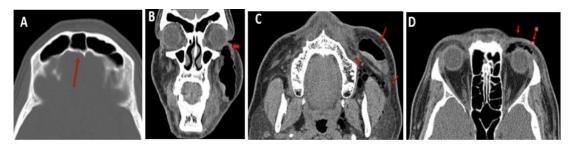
CT image showing A: Hairline fracture involving the posterior wall of frontal sinus. B : coronal section showing diffuse hypodensity involving the left maxillary and infraorbital fascial planes. C : Axial section showing subcutaneous edematous changes.
